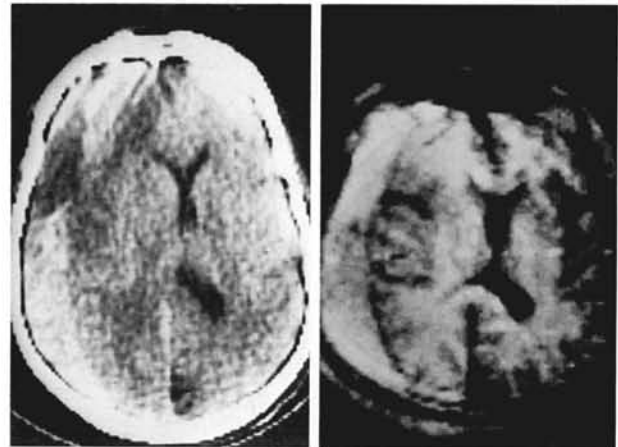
Chronic subdural hematoma exhibits hypodense and hyperdense areas on noncontrast CT scan (a) and is clearly visualized in the inversion recovery 1,500(400)/30 image at 0.17 T (b).
